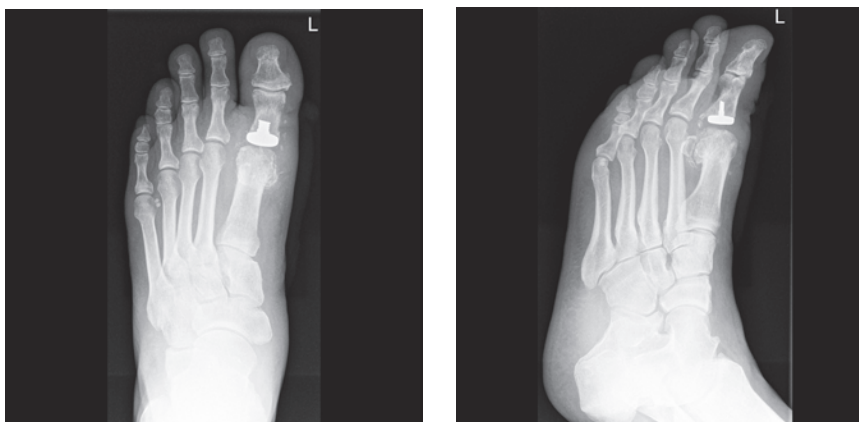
Radiographs 17 months postoperative.
